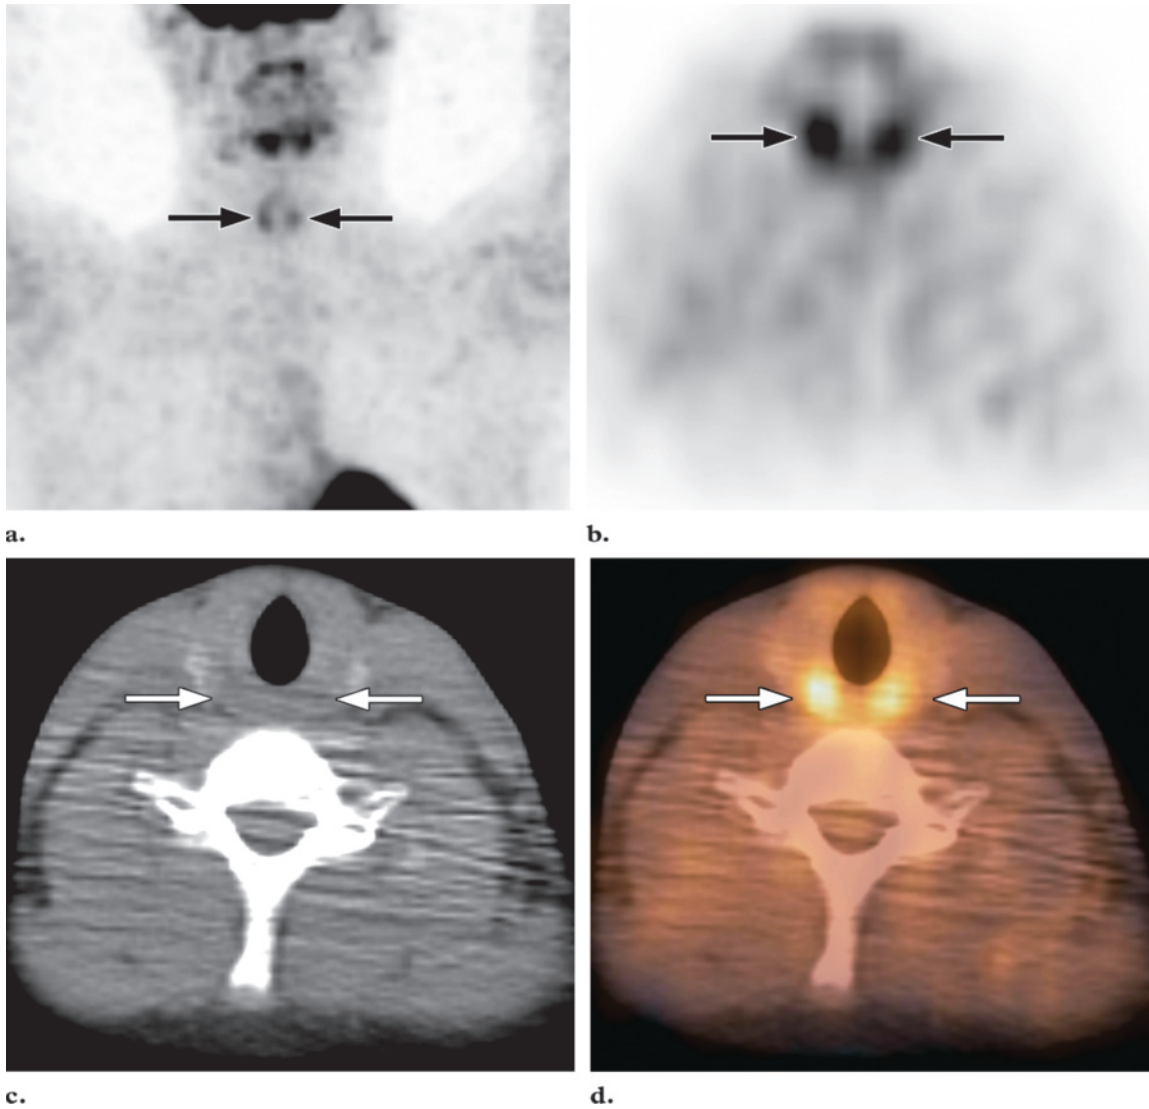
MIP FDG PET image (a) and transverse FDG PET (b), CT (c), and fused PET/CT (d) images show mildly increased uptake in the arytenoid muscles (arrows).
